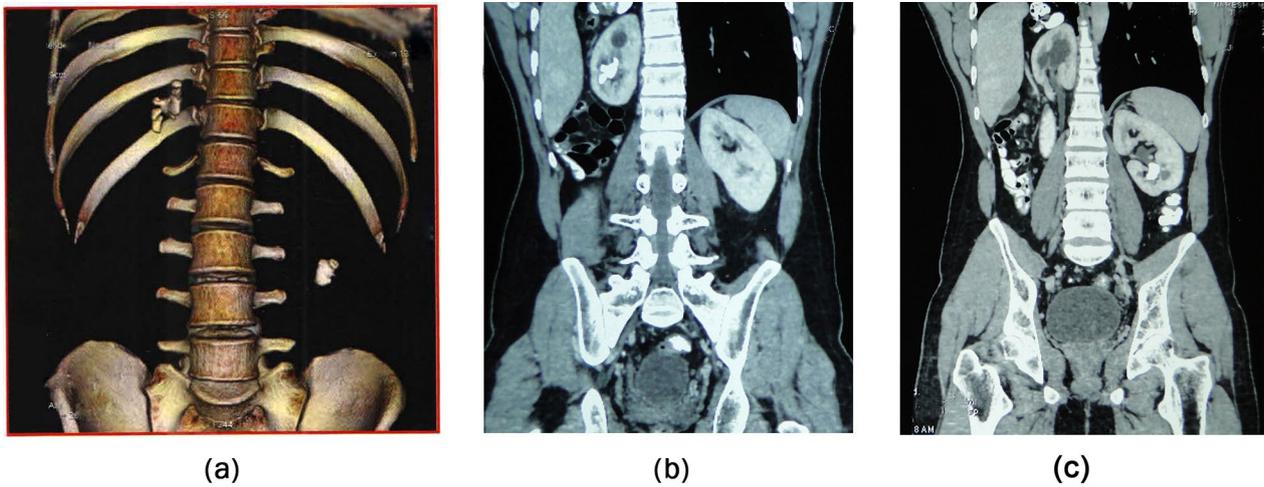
a CT showing bilateral partial staghorn calculus with right partial staghorn calculus located in the thoracic cavity. b CT showing partial staghorn calculus in right thoracic kidney. c CT showing partial staghorn calculus in orthotopic left kidney
